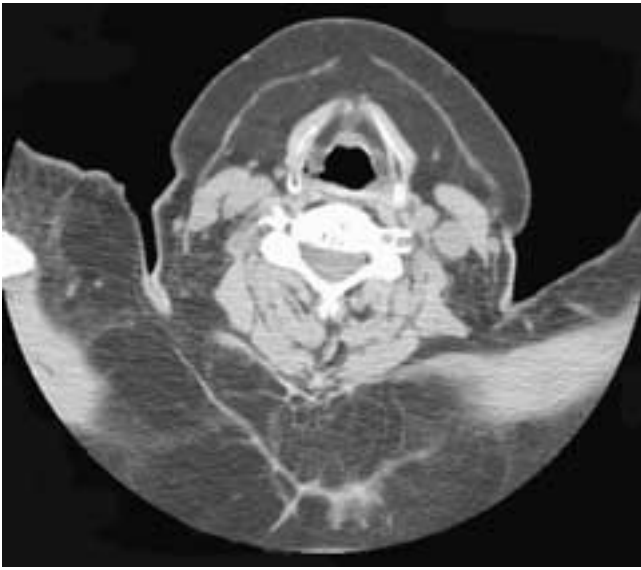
Axial CT scan shows extensive fat in the subcutaneous soft tissues of an obese patient. There are no discrete, well-defined collections of fat, as seen in Madelung's disease.
